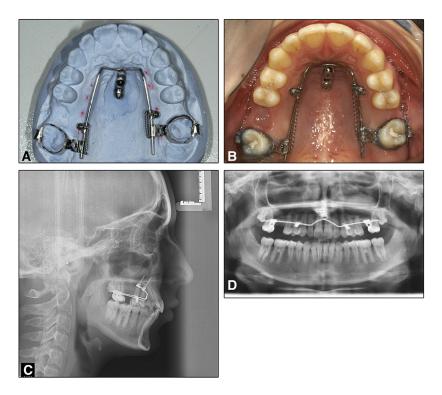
A, Mesialslider adapted on a plaster model. B, Intraoral photograph after placement of palatal mini-implants and the Mesialslider. C, D, radiographs after placement.
